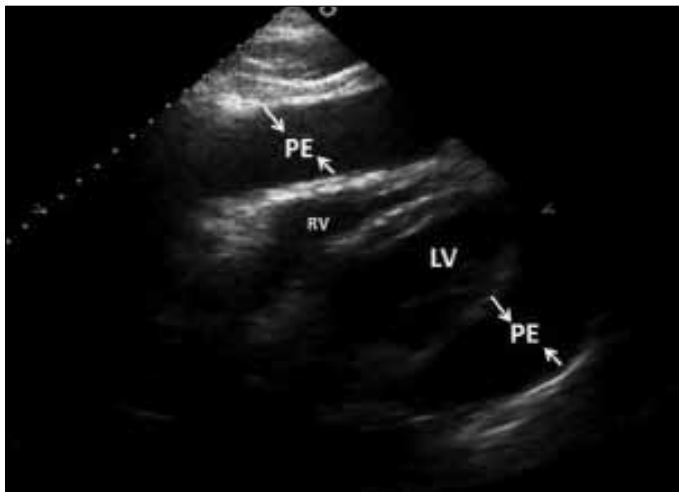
Transthoracic echocardiography shows massive pericardial effusion (arrow) in a patient with ALL in subcostal view
